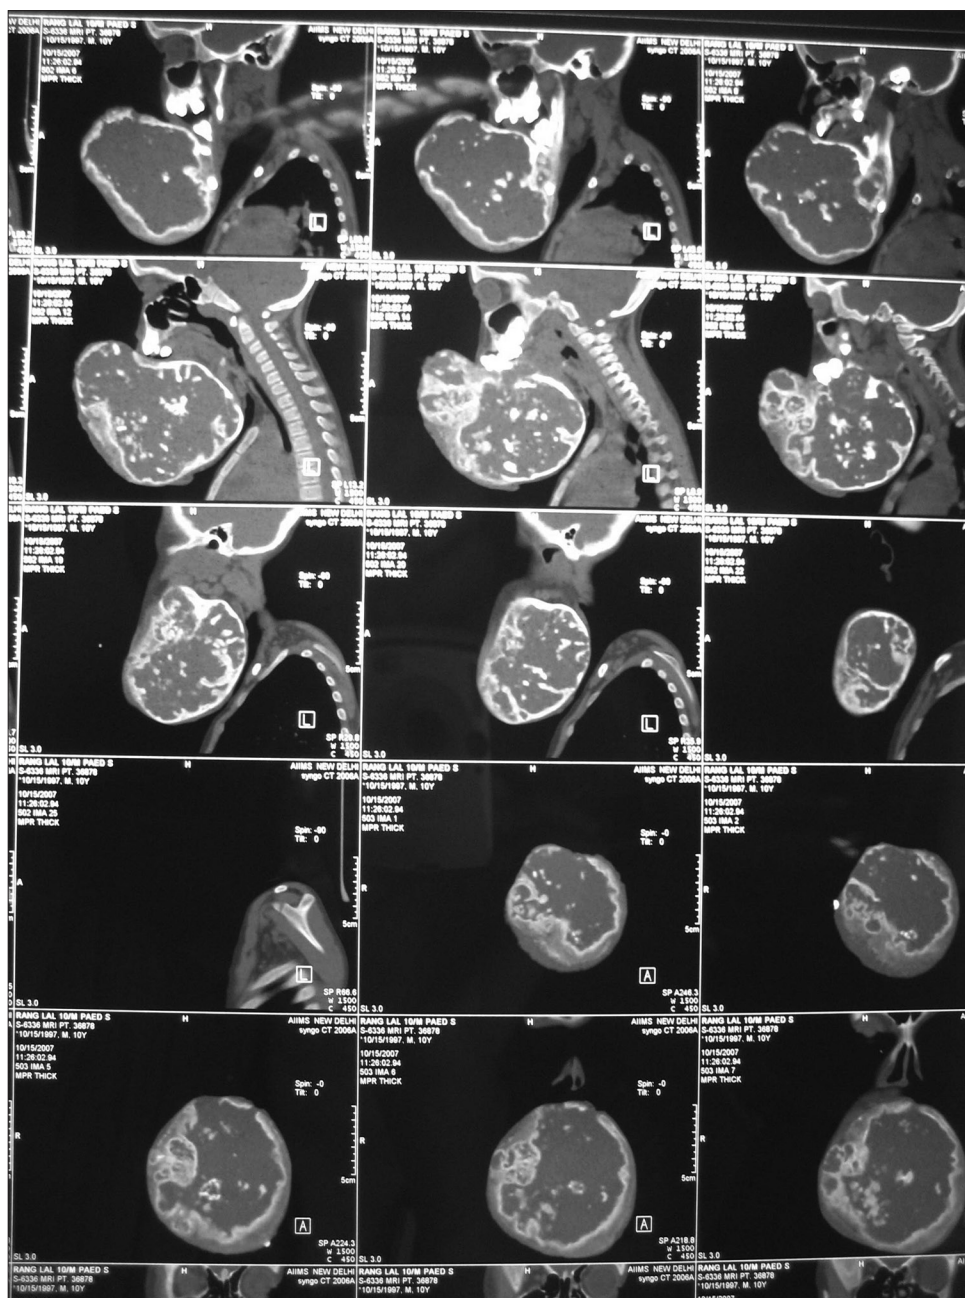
Computed tomography scan showing extent of airway involvement and degree of sparing (important for planing to secure airway)
